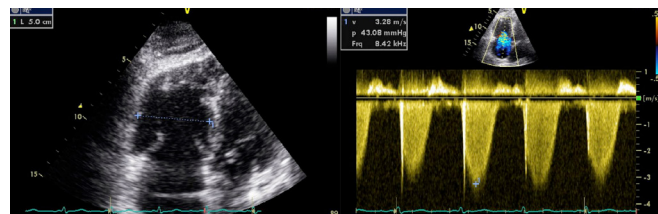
Preoperative echocardiogram showing dilated right ventricle (left) and severe tricuspid regurgitation (right).
